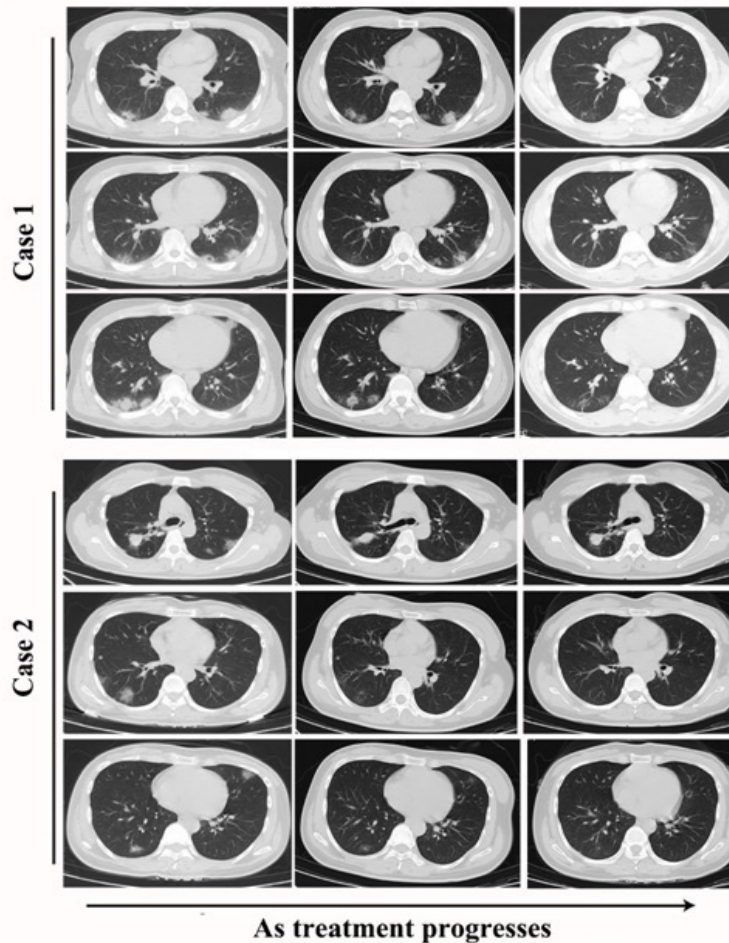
Evolution of the lesions on chest CT of two patients with COVID-19 and TB co-infection (Case1 is a male patient and case 2 was a female patient). As treatment progresses.
